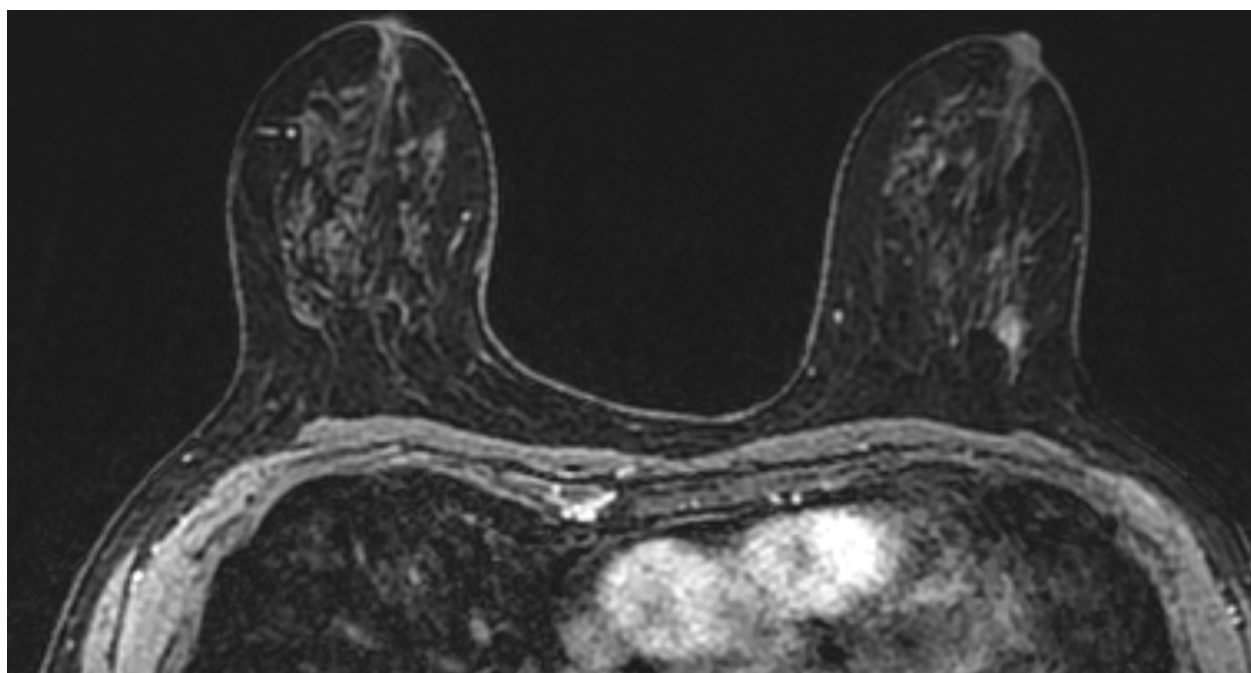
MRI with intravenous contrast was performed, as no lesions had been detected on the initial ultrasound. The MRI showed a focus with contrast enhancement and non-specific dynamic curves, corresponding to the same location as the PET-CT finding in the left breast at 3 o'clock.
